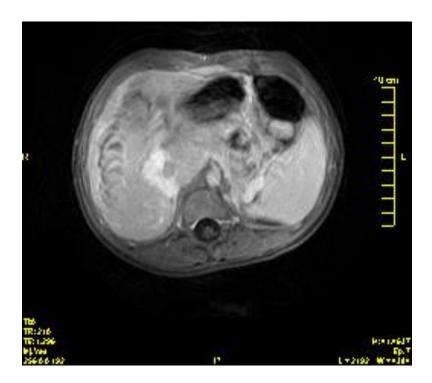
Patient A. MRI presenting a wide shunt between the right branch of the portal vein and the IVC.
